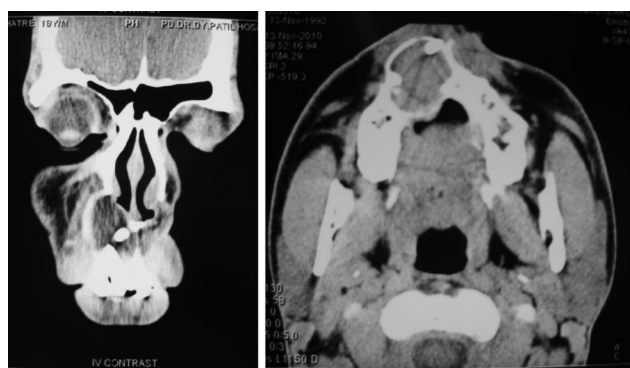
Coronal and axial CT views.
